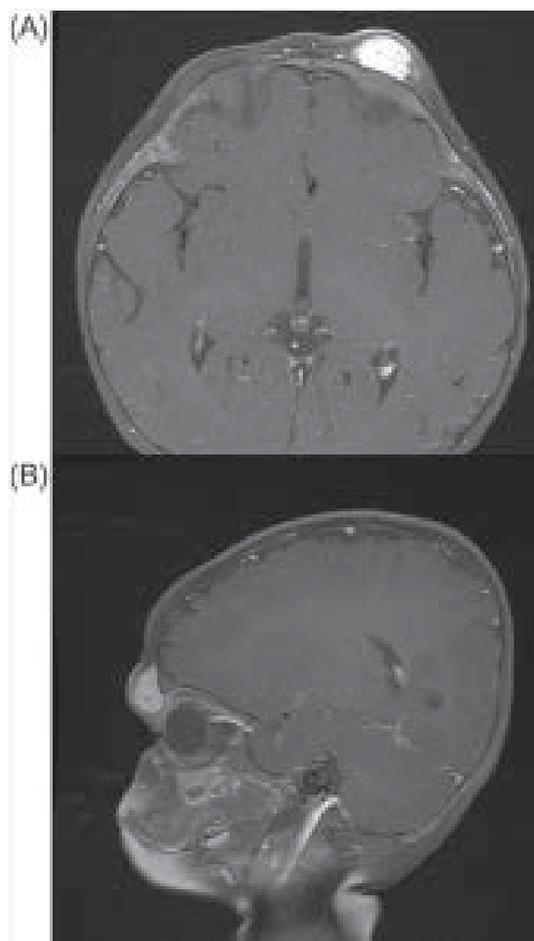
Magnetic resonance imaging displaying in T1 post-contrast axial (A) and front-to-back (B) well bordered, clearly shining lesion of left forehead and upper eyelid
